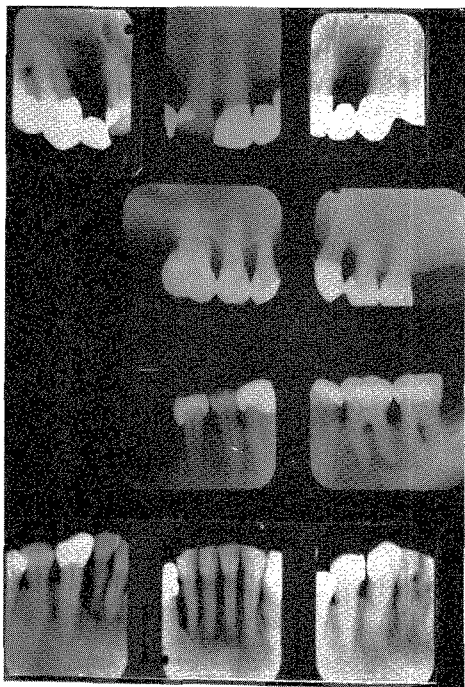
These roentgenograms were taken in 1961. The oral structures remained stable ever since treatment was completed twelve years previously.
